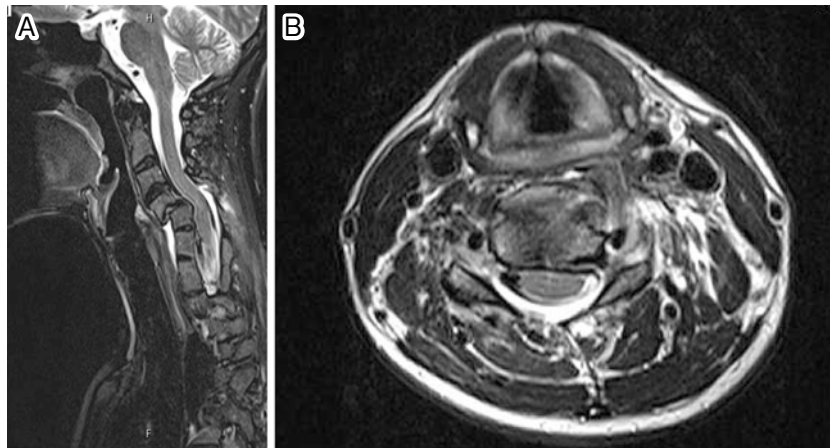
Preoperative Cervical Spine Magnetic Resonance Imaging (MRI)
